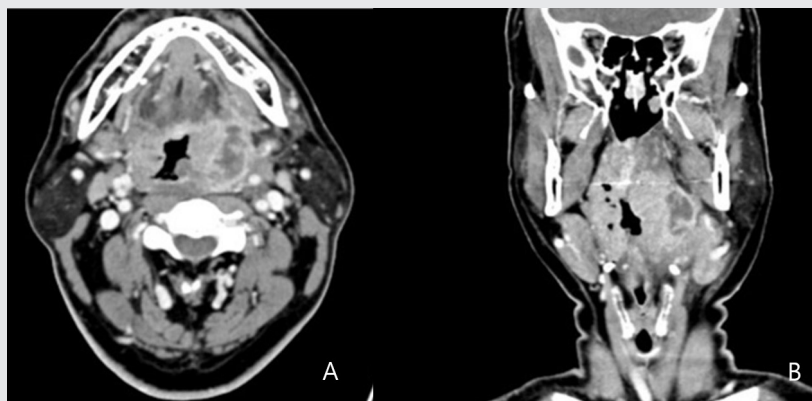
A. Axial view of CT. An edema is observed in the left pharynx. The central part of the edema shows low density, and the peripheral part shows peripheral enhancement, which is considered an abscess. B. Coronal view of CT. A slight cellulitic change of fat in the parapharyngeal space is observed.
